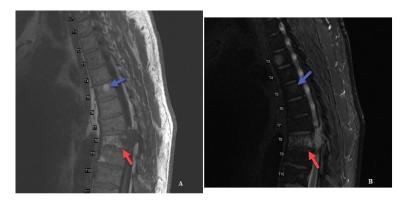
A: A 61-year-old male with hemangioma of the thoracic spine. Sagittal T1W MRI demonstrated two hemangiomata at fifth and eighth thoracic vertebrae. Benign hemangioma at T5 shows increased T1 signal (Blue arrow). Aggressive epithelioid hemangioma at T8 with epidural extension and mass effect on the cord also shows increased T1 signal (Red arrow). B: A 61-year-old male with hemangioma of the thoracic spine. Sagittal T2W Fat Saturation MRI demonstrated two hemangiomata at fifth and eighth thoracic vertebrae. Benign hemangioma at T5 shows increased T2 signal (Blue arrow). Aggressive epithelioid hemangioma at T8 with epidural extension and mass effect on the cord also shows increased T2 signal (Red arrow)
